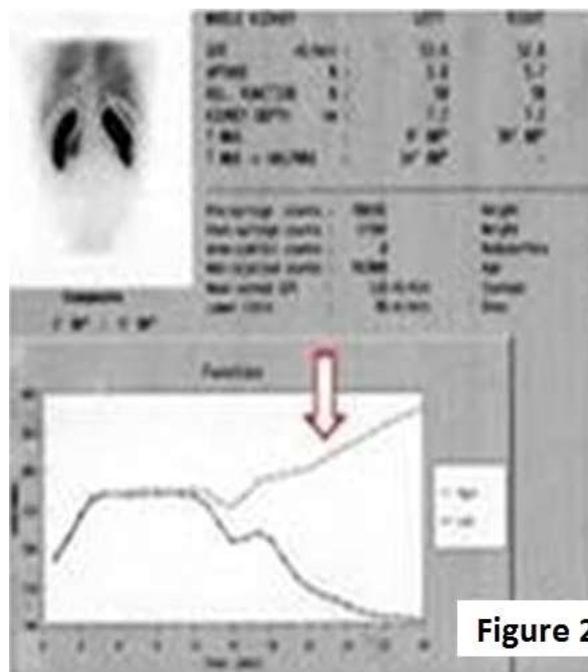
Renal scintigraphy shows radionuclide accumulation on affected side
